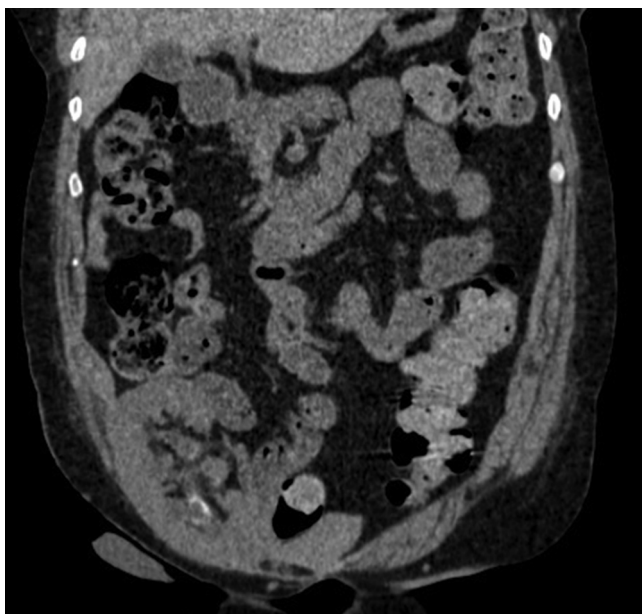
Computed tomographic scan following treatment, showing almost complete radiological resolution, with a small area of residual calcification in the lower pole of the transplant kidney.
